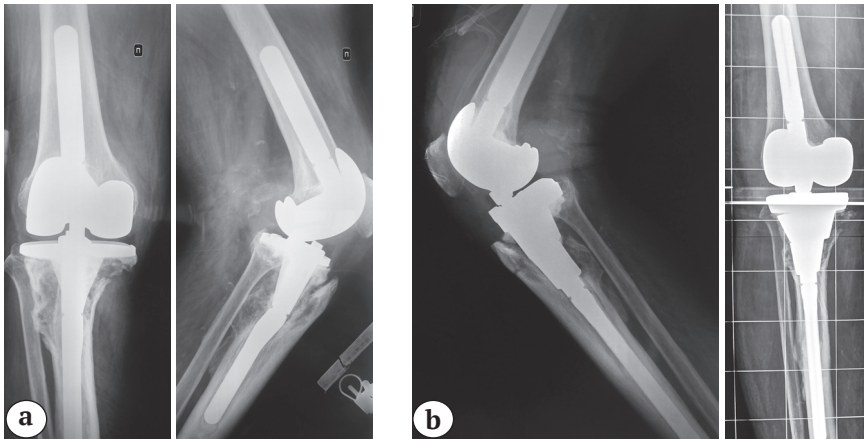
A clinical example of the use of the double tantalum cones for revision knee arthroplasty due to the instability of endoprosthesis components and periprosthetic tibial fracture: a — X-rays before the surgery; b — X-rays after the surgery.
